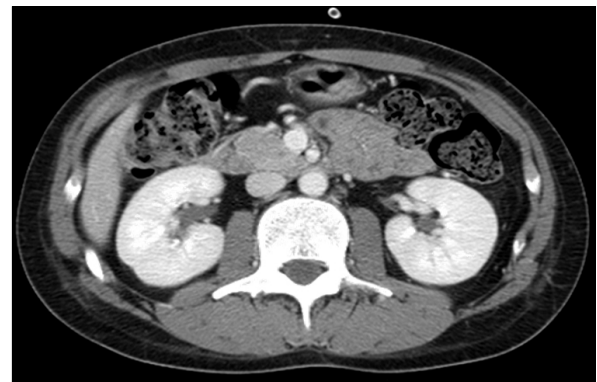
Abdominal CT after chemotherapy. Abdominal CT after chemotherapy reveals normalization in the size of both kidneys.
